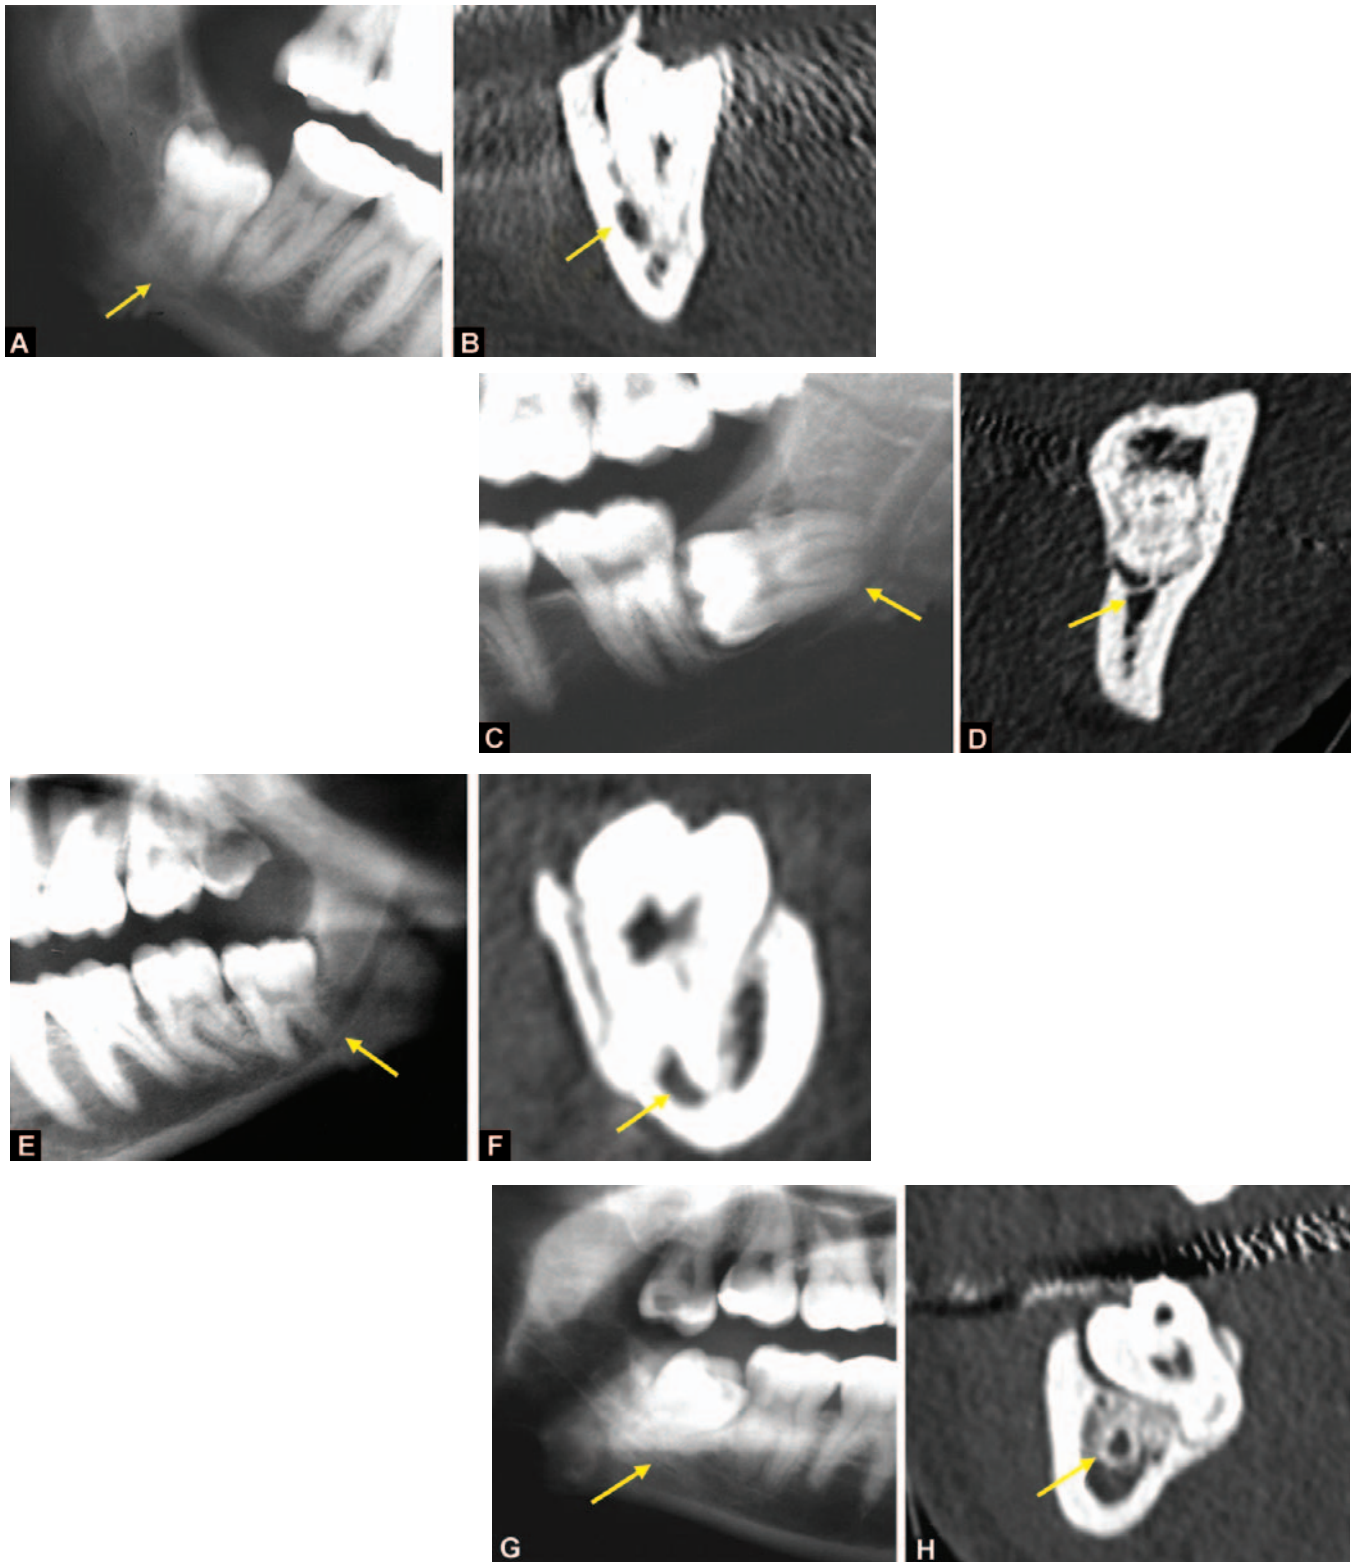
to J: Reformatted CT images showing various relationships between the inferior dental canal and the lower third molar roots. (G) Lingual positioning and narrowing of the canal and thinning of the adjacent cortex, (H) Buccal positioning and minor thinning of the adjacent cortex, (I) Inferior positioning of the canal without narrowing, (J) The canal between the roots and with narrowing (Adapted with kind permission from Mahasantiya et al. Narrowing of the inferior dental canal in relation to the lower third molars *Dentomaxillofacial Radiology*. 2005; 34: 154-163)
